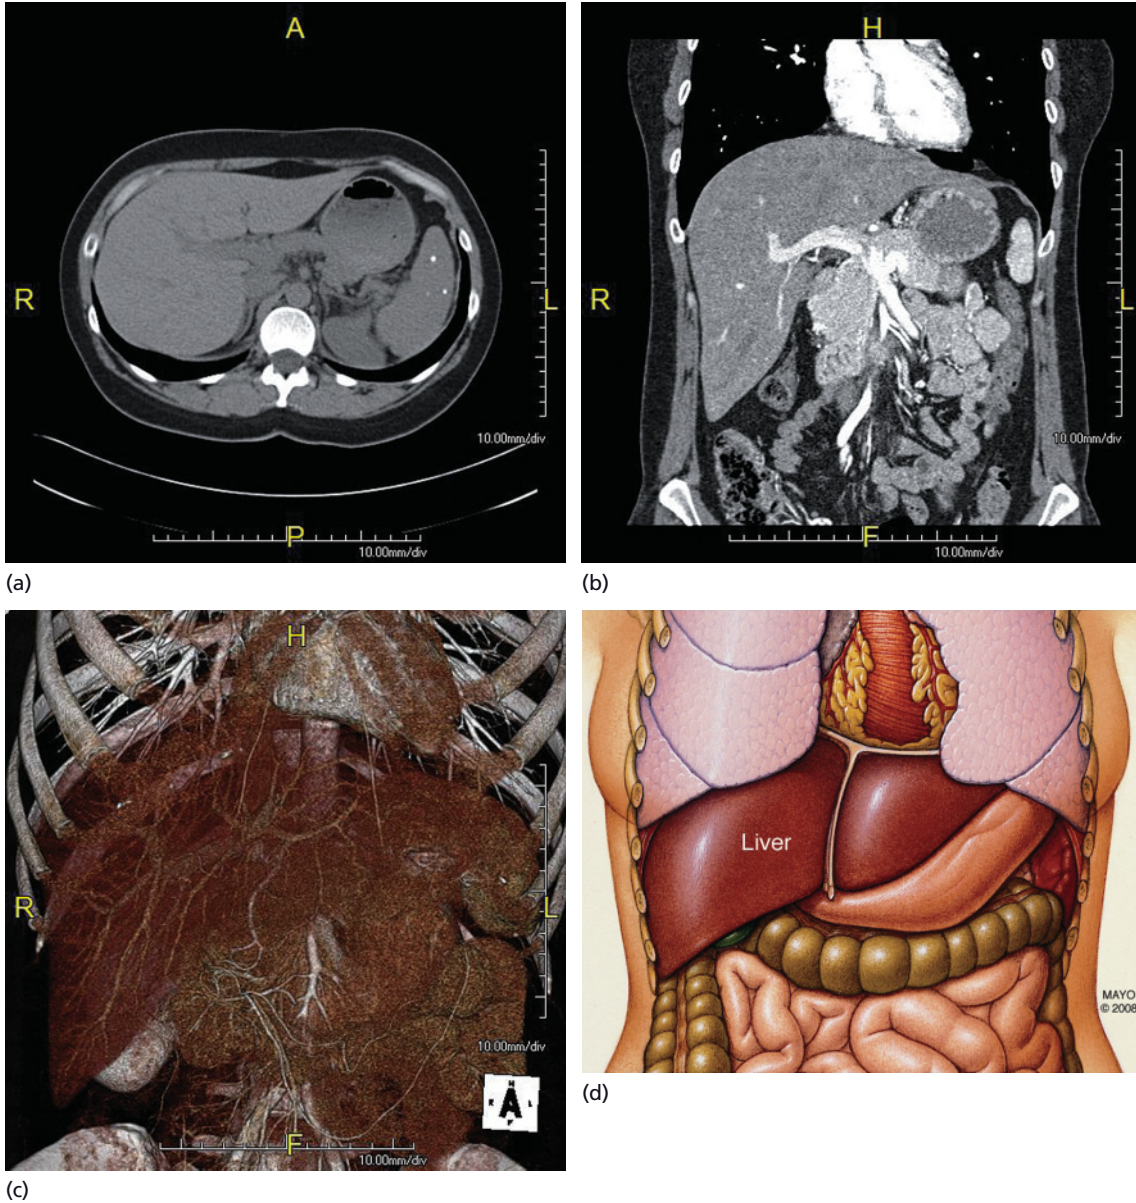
CT scans of liver *in situ*: (a) horizontal plane; (b) coronal plane. (c) Three-dimensional image of liver; (d) anterior view of liver in abdominal cavity. (Image (d) is courtesy of RF Morreale, 2008.)
